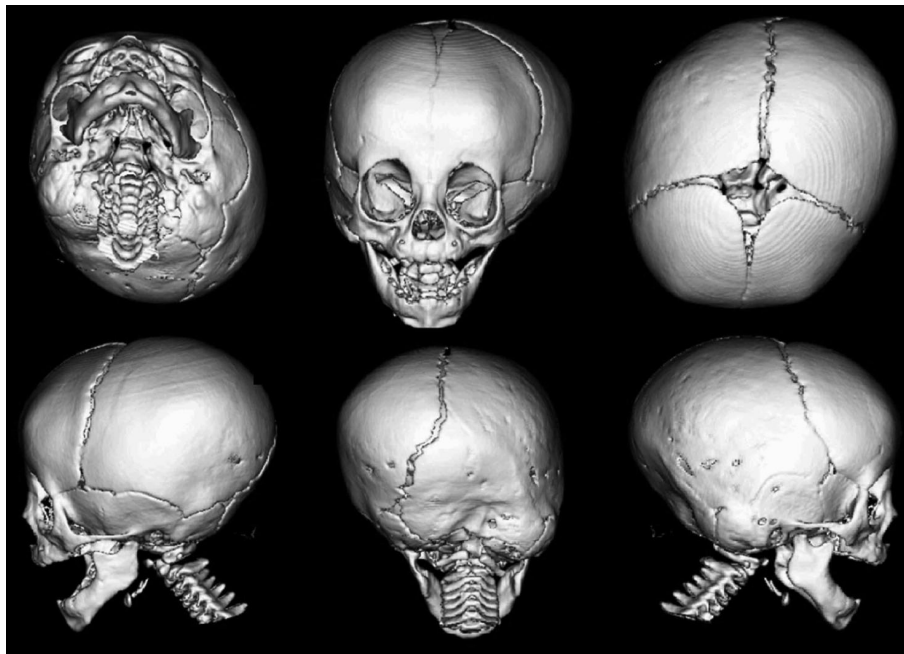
Preoperative 3D CT scan of 9 months old patient with unilambdoid craniosynostosis. There is an apparent plagiocephaly with deviation of the skull axis towards the unaffected side.
